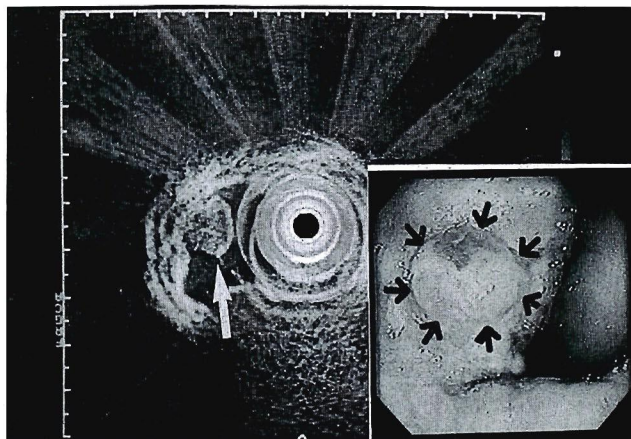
Endoscopic ultrasonography demonstrating a polypoid tumor with no evidence of penetration into the proper muscle layer. Colonoscopy (the inset at the lower right) showing the tumor with no brown to black pigmentation.
